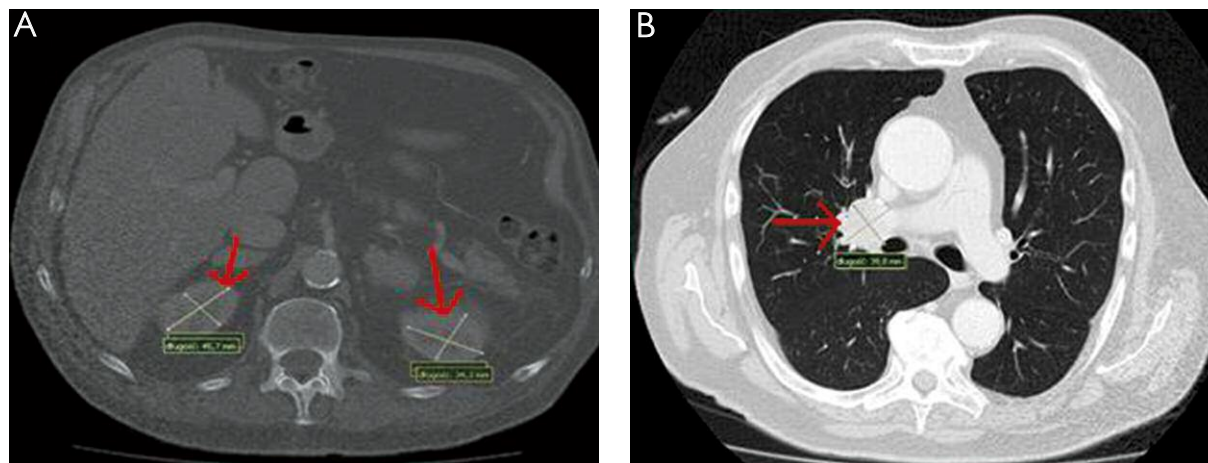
Computed tomography. Metastases in abdominal organs (A), tumor in the hilus of the right lung (B)
